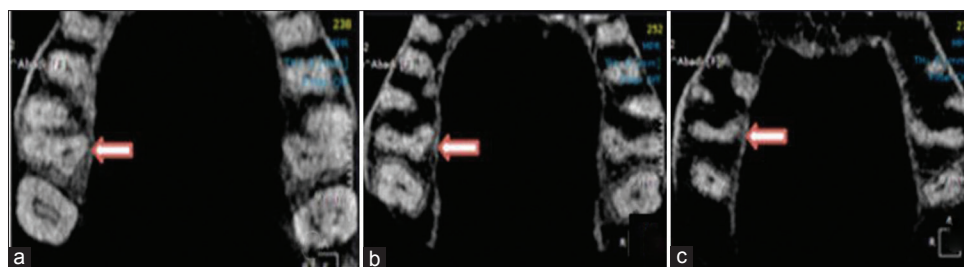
Cone-beam computed tomography images of maxillary first molar showing Type VI root canal morphology of (2-1-2) in mesiobuccal root in axial direction, (a and b) two canals, (c) joined into one canal, (d and e) redivided onto two canals
